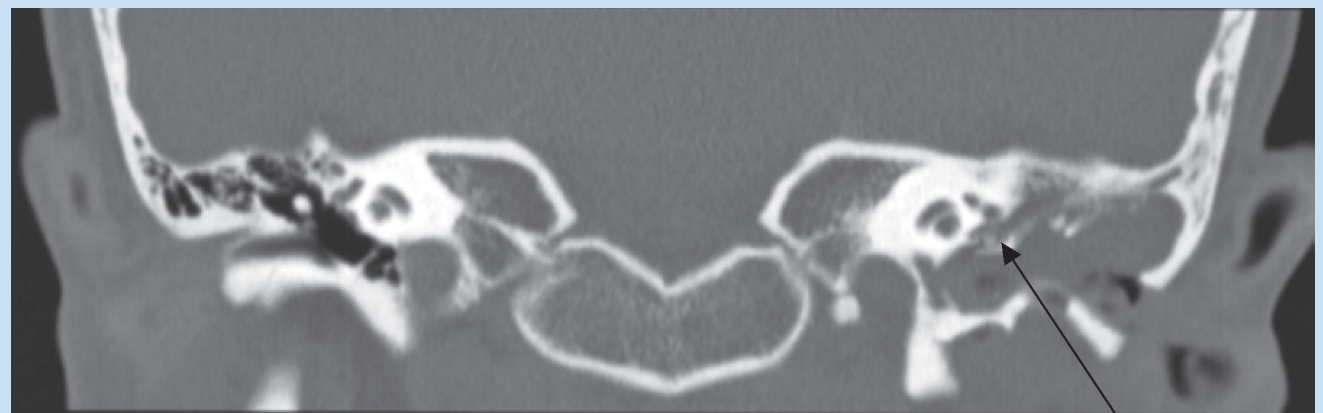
Coronal CT with semi-circular erosions (arrow).
